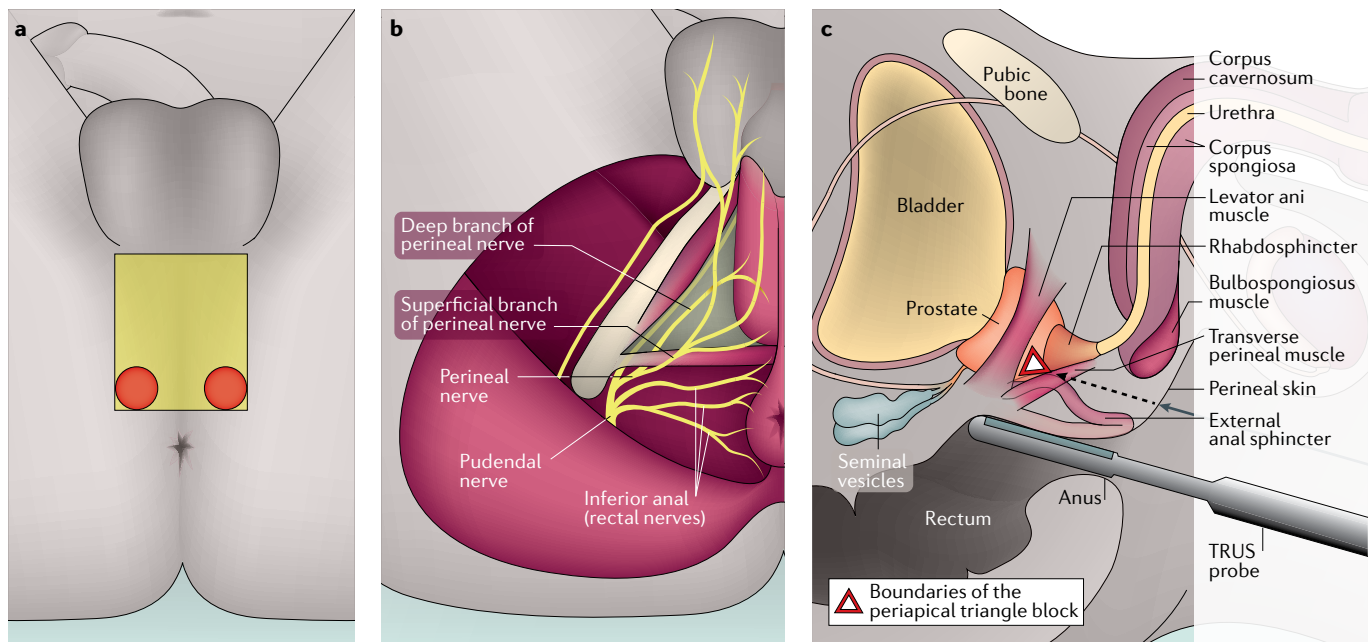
Methods for administering local anaesthesia during transperineal prostate biopsy. a | External inferior view of the perineum highlighting areas of skin that need to be anaesthetized for transperineal prostate biopsy with the grid-based (yellow square) and freehand (red circles) approaches. b | Inferior view of the perineum showing the muscles of the pelvic floor and their innervation by the pudendal nerve and its branches. c | Sagittal view of the male pelvis showing the location of the periapical triangle block. The periapical triangle is bounded by the medial edge of the levator ani muscle, the urethral rhabdosphincter and the external anal sphincter muscle. TRUS, transrectal ultrasonography.
